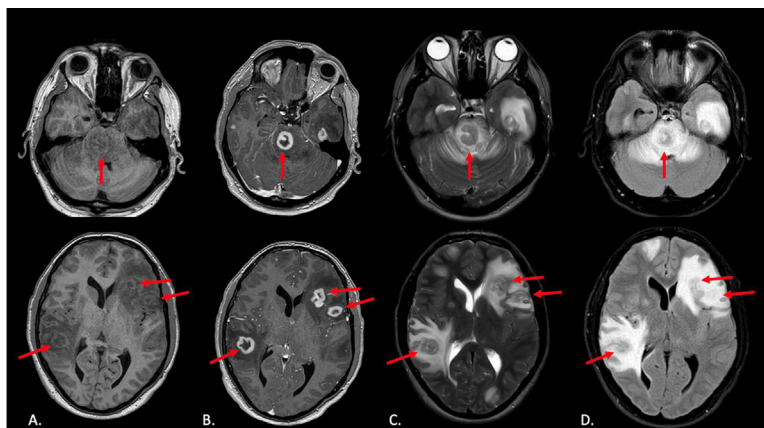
Axial sections of an MRI with and without intravenous contrast demonstrates numerous enhancing supratentorial and brainstem lesions, with significant surrounding edema and mass effect (red arrows). Column A. is a T1 weighted image. Column B is a T1 weighted, post-gadolinium image. Column C is a T2 weighted image. Column D is a T2 FLAIR image.
